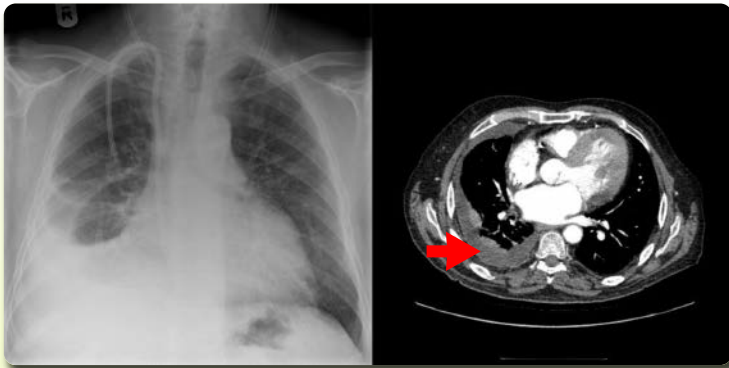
Chest radiograph and computed tomography scan of thorax show a right-sided effusion (arrow).
